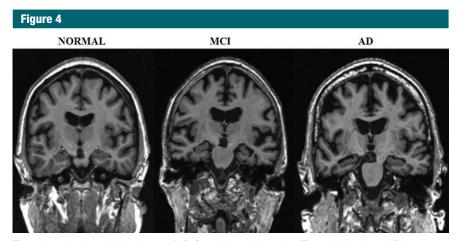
Atrophy and clinical stage of AD. Coronal three-dimensional T1-weighted volume MR images (repetition time msec/echo time msec/inversion time msec, 7/900/2.8/900) in three individuals in their 70s are shown. The cognitively normal control subject shows little atrophy; the AD subject, considerable atrophy; and the MCl subject, an intermediate level of atrophy.
